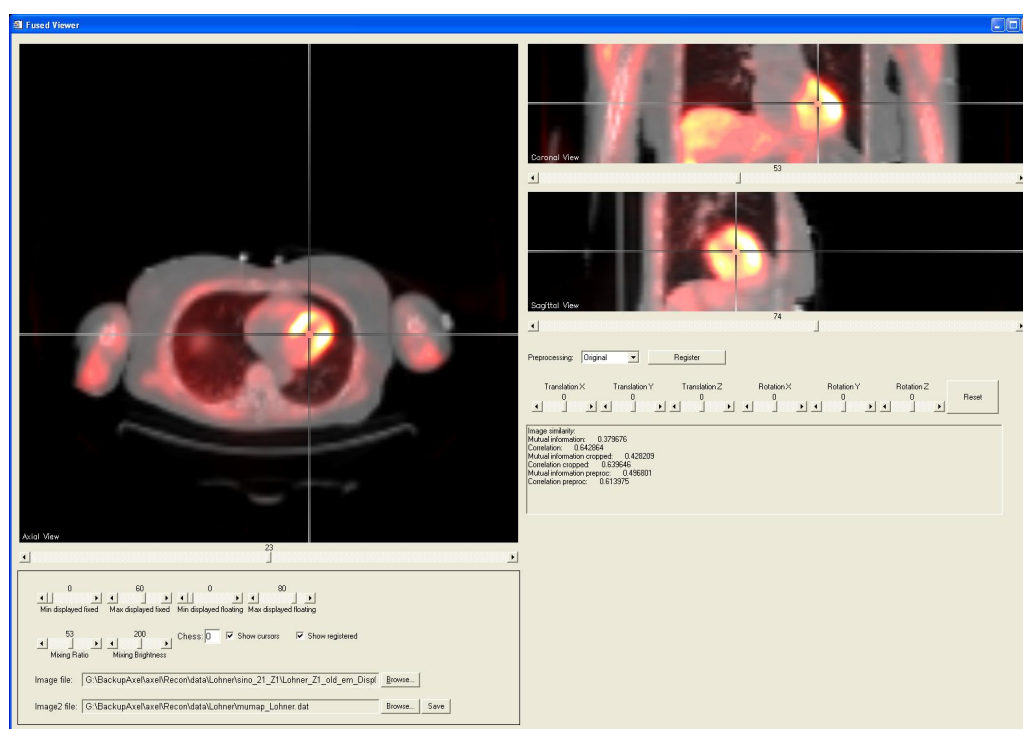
Screenshot of the IDL program to perform the PET-CT image registration, showing the fused images in transaxial, coronal and sagittal views.
